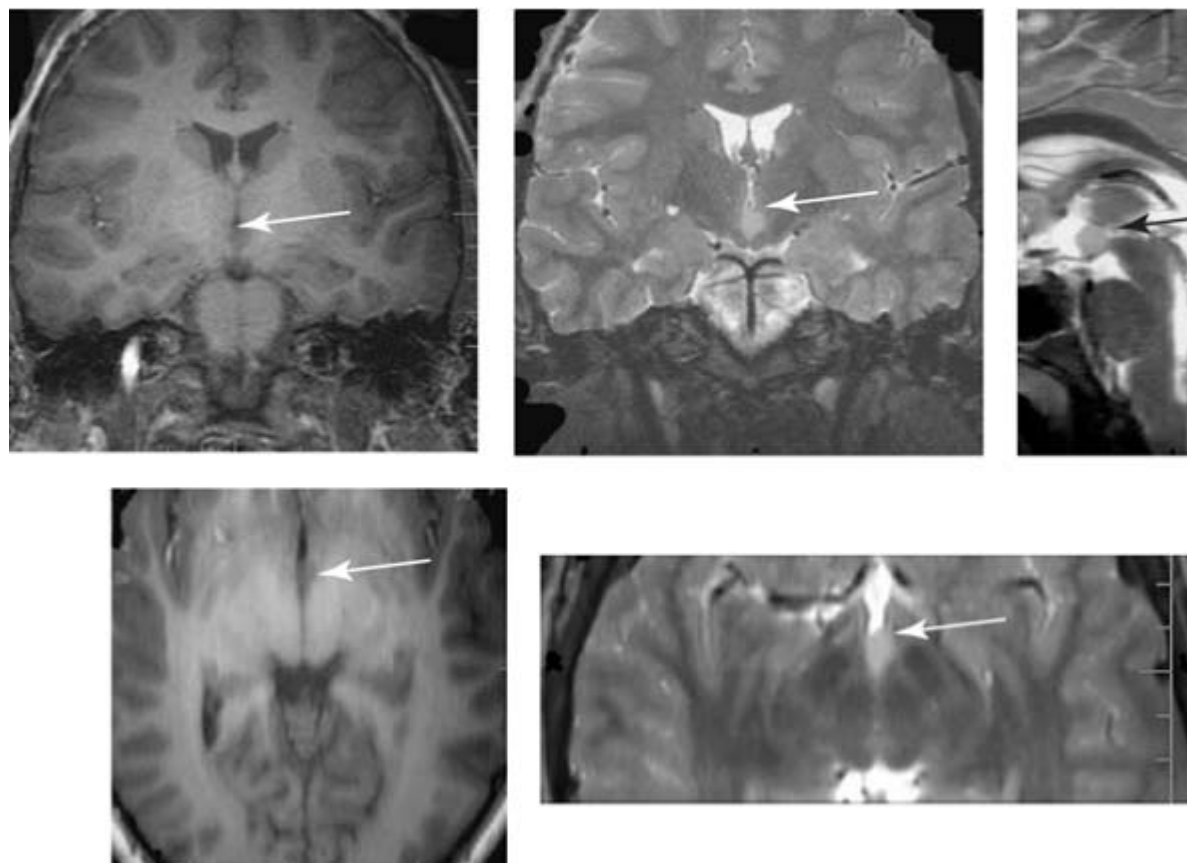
Hypothalamic hamartomas can be seen in the third ventricle. They are small and can easily be missed. They should be specifically looked for in all cases of temporal lobe epilepsy or partial epilepsy in which the magnetic resonance imaging is otherwise considered to be normal. (Image courtesy of Simon Harvey, Royal Children's Hospital, Melbourne, Australia.)
